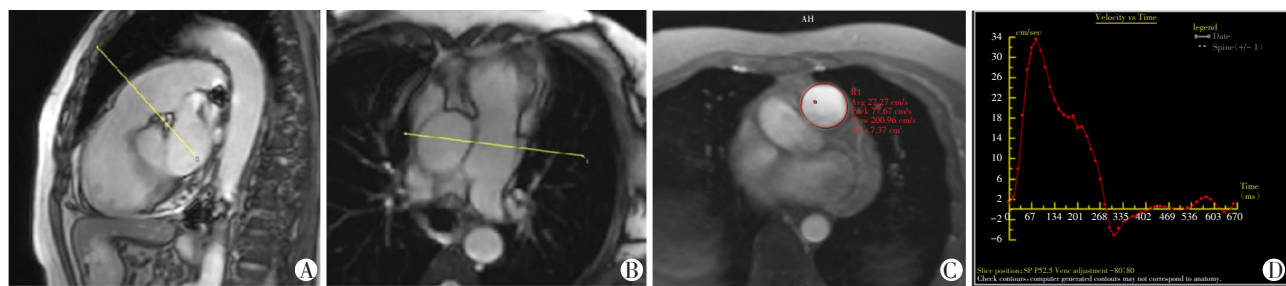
MPA PC-MRI scanning location and measurement method
